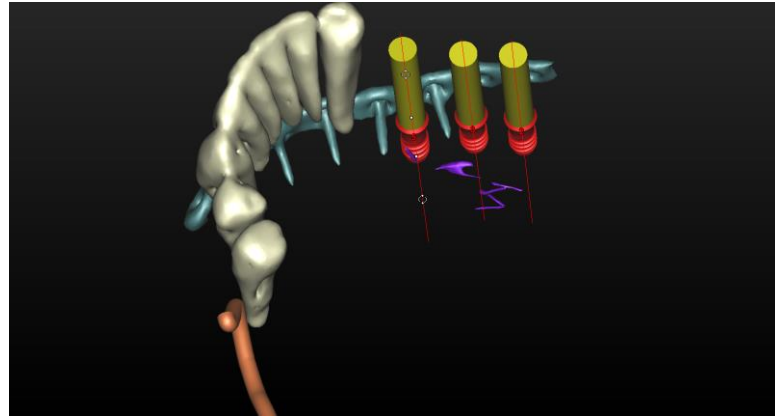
CBCT image segmented in digital planning software with the bone removed allowing visualisation of the planned implant placement avoiding the reconstruction screws and plates (blue).
